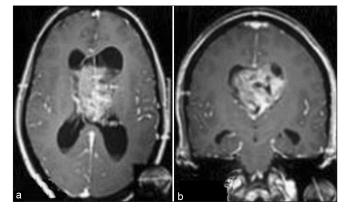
Contrast MRI axial (a) and coronal (b) section showing heterogenous, enhancing lesion primarily in left lateral ventricle pushing the septum pellucidum to right and also extending to the other side
